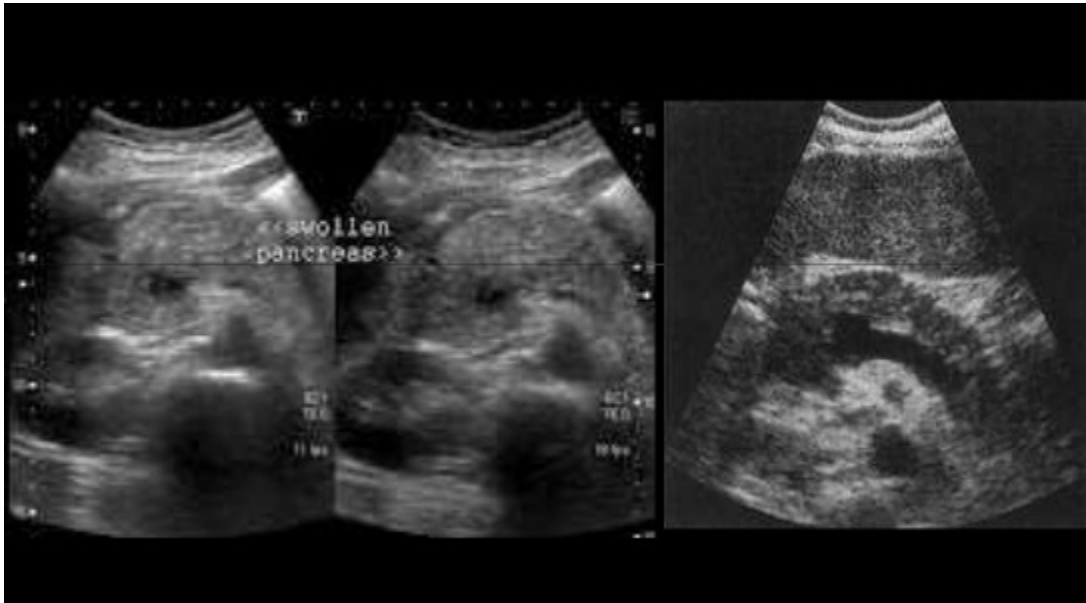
X-Rays of acute pancreatitis
